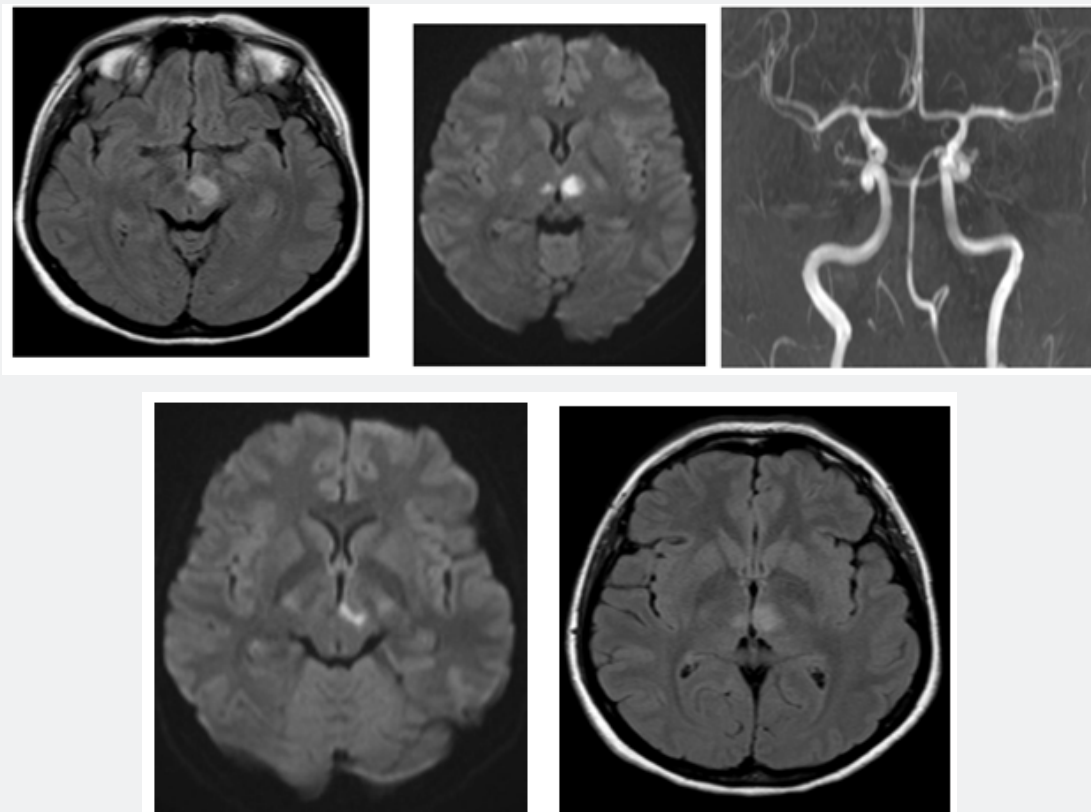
MRI brain showed bilateral paramedian thalamic infarcts extending into the midbrain with a reduced signal on the apparent diffusion coefficient images indicating restricted diffusion in keeping with acute bilateral medial thalamic infarcts and petechial micro-hemorrhagic in the midbrain.
